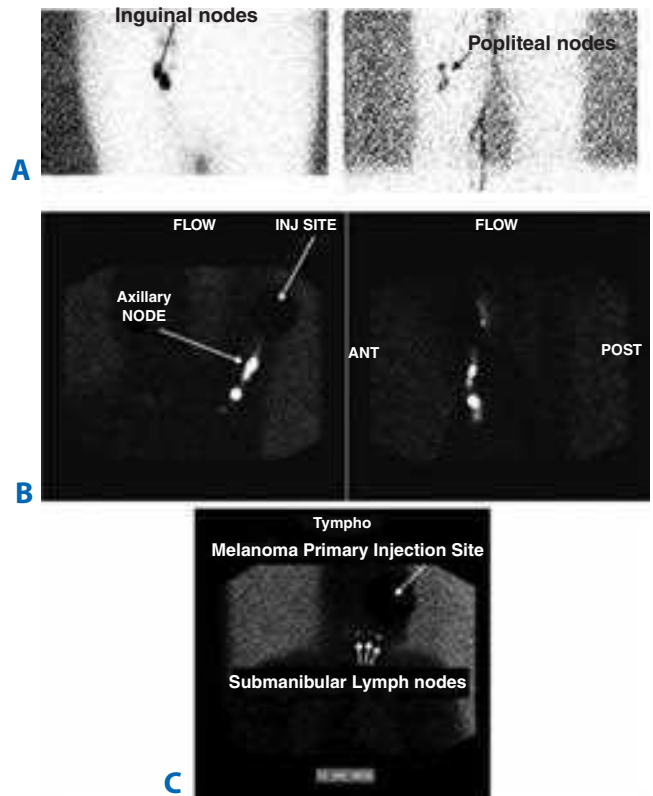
After injection of radioactive technetium-99–labeled sulfur colloid tracer at the primary cutaneous melanoma site, sentinel lymph node basins are identified. A. Lymphoscintigraphy of 67-year-old male with a malignant melanoma of the right heel; sentinel lymph nodes in both the right popliteal fossa and inguinal region. B. Lymphoscintigraphy of 52-year-old male with a malignant melanoma of the posterior right upper arm; sentinel lymph node in the right axillary region. C. Lymphoscintigraphy of 69-year-old male with a facial melanoma; sentinel lymph nodes in the submandibular region. ANT = anterior; INJ = injection; POST = posterior.
